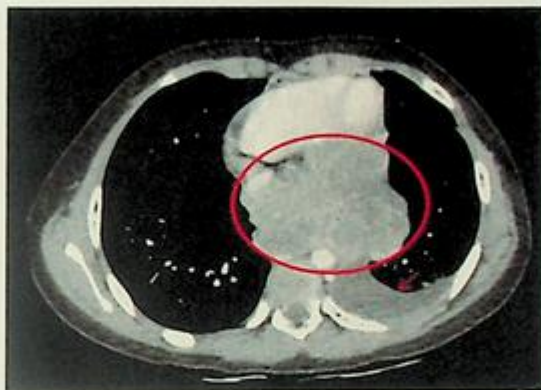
MRI of the mediastinal mass lesion. There was a thoracoabdominal mass involving the middle/posterior mediastinum to the superior retroperitoneum, measuring $10.4 \times 9.4 \times 6.0$ cm (red circle) and left pleural effusion (red circle).
